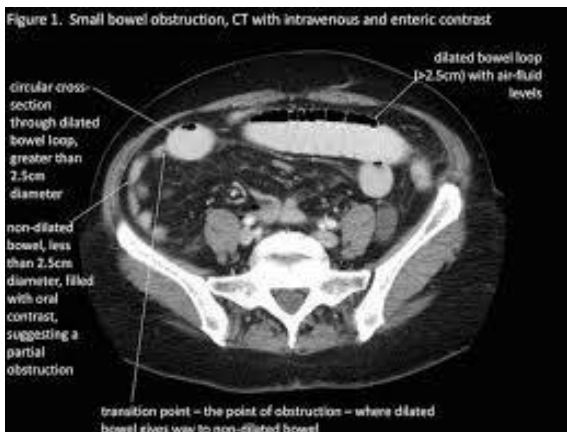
CT Scan in Small Bowel Obstruction
